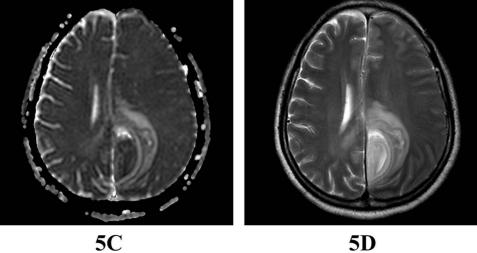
Cranial MR enhancement on August 13: Multiple abnormal signals were observed in the left frontoparietal lobe, the corpus callosum splenium, and the left temporal pole, along with thickening and abnormal enhancement of the meninges and empyema adjacent to the cerebral falx and tentorium cerebelli. (A) DWI sequence showing abnormally high signal in the left lateral semicircle of the cerebral falx, locally wrapped, with high signal on DWI. (B) Enhanced scan showing abnormally high signal in the left lateral semicircle of the cerebral falx, local meningeal thickening, abnormal strengthening, and considered considered to be empyema. (C) ADC sequence showing abnormally high signal in the left side semicircle of the sickle, local encapsulation, hypoperfusion, and limited diffusion. (D) T2 sequence showing abnormally high signal in the left side semicircle of the brain, localized wrapping, and surrounding swelling.
